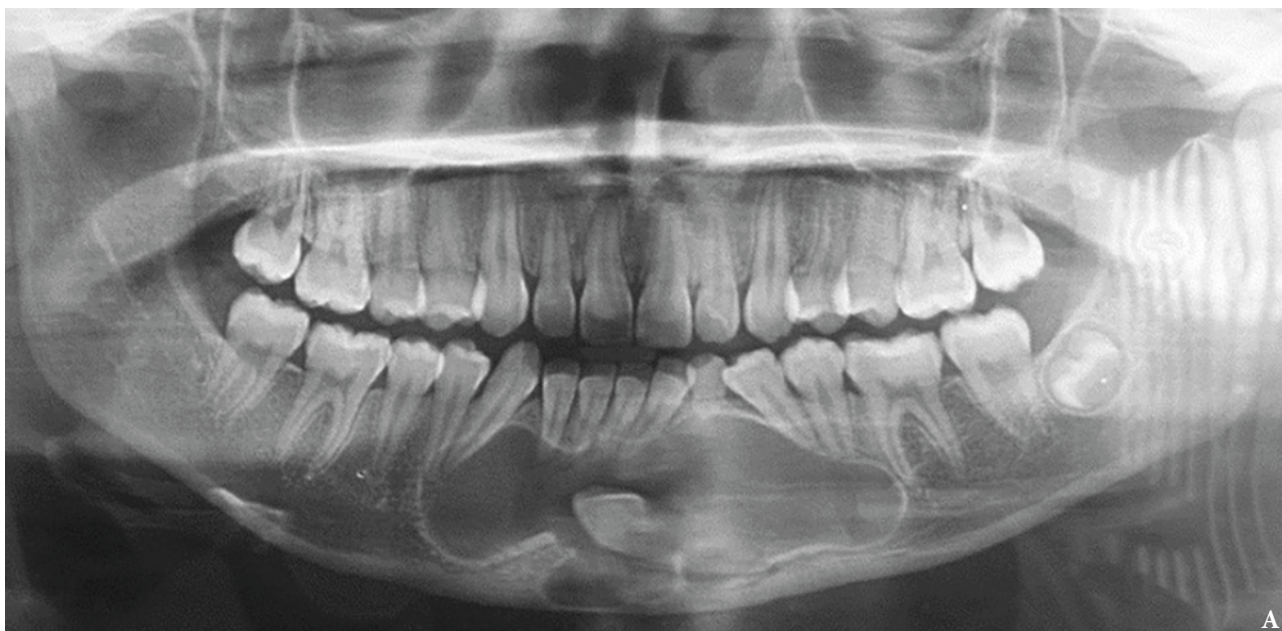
Case 4. A: Initial X-ray. B: Lesion size scheme (green) for resection.
